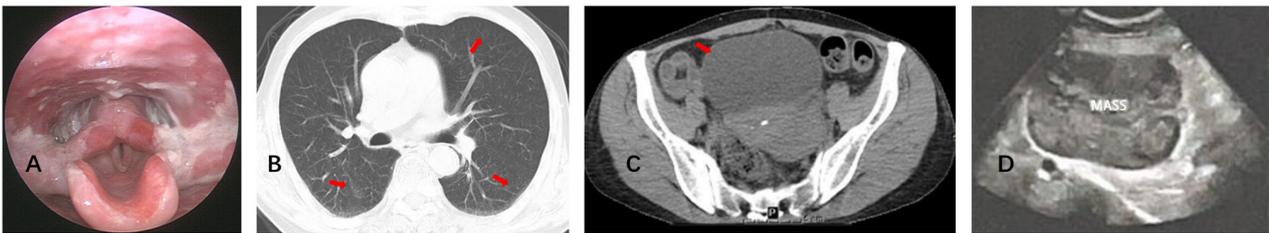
Laryngoscopy and imaging findings. (A) Erosions and white pseudomembranous exudates on laryngoscopy. (B) The imaging revealed bronchitis and mild bronchial dilation in both lungs (indicated by red arrows). (C) Pelvic CT plain scan exhibited a solitary mass in the left pelvic region (indicated by red arrow). (D) Transvaginal ultrasonography showing a hypochoic mass measuring ~114x86x118 mm.
